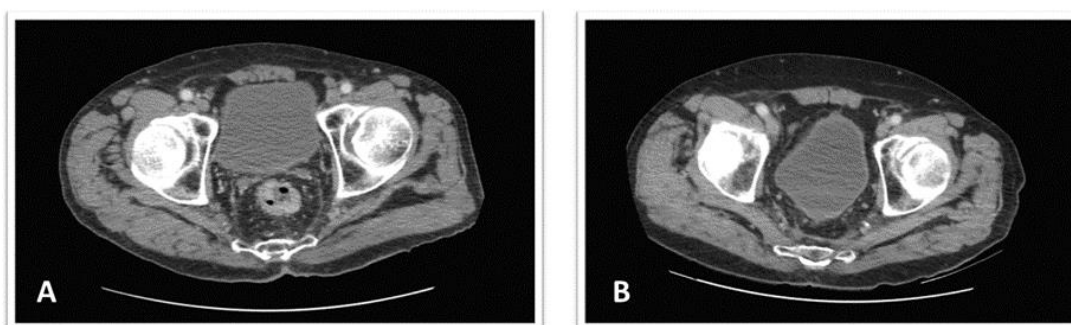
Computed Tomography axial slice of the pelvis. A – captured on 06.01.2020, showing a low rectal tumor obstructing the lumen. B – captured on 01.06.2021, showing no local recurrence of low rectal cancer at 6-months after neoadjuvant chemotherapy and abdominoperineal surgery
